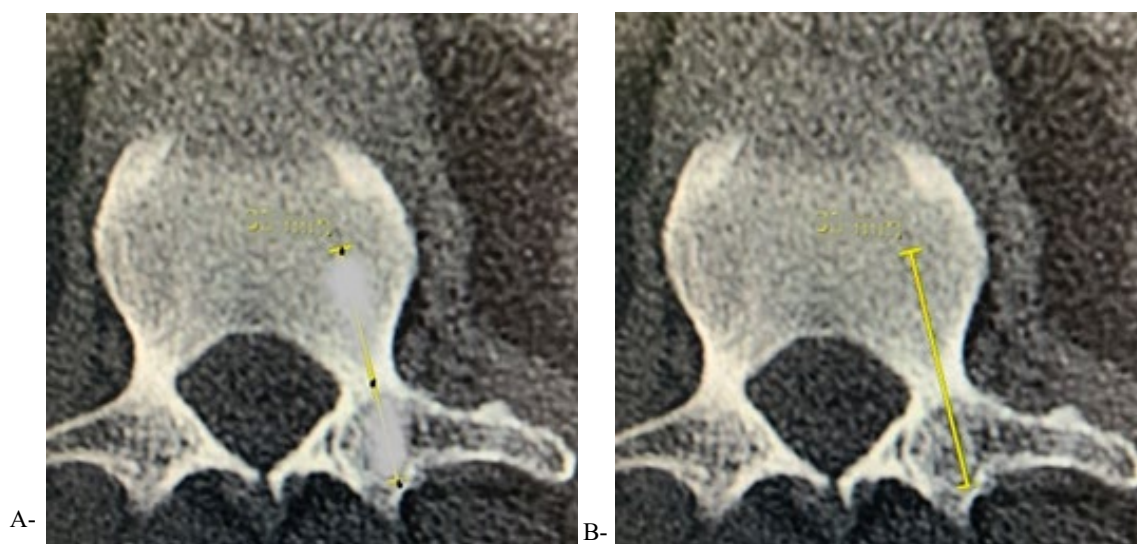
A-B: shows an axial cut of the lumbar CT: A-shows the 3-dot registered on the navigation system. B-displays the correct line when the correct points are targeted.
